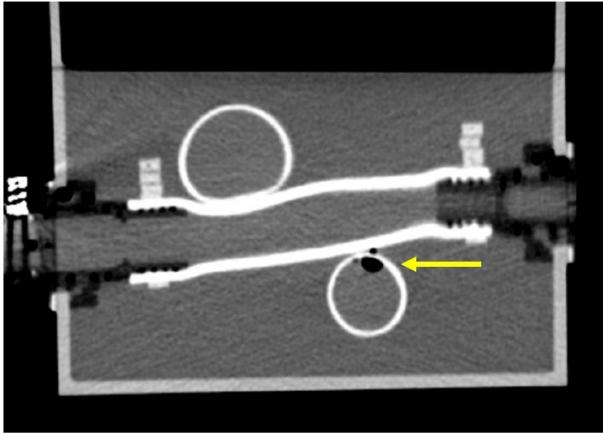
CT image demonstrating the presence of a static air bubble with a volume of 0.1 mL. The bubble, located by the yellow arrow, is clearly visible in the image.
